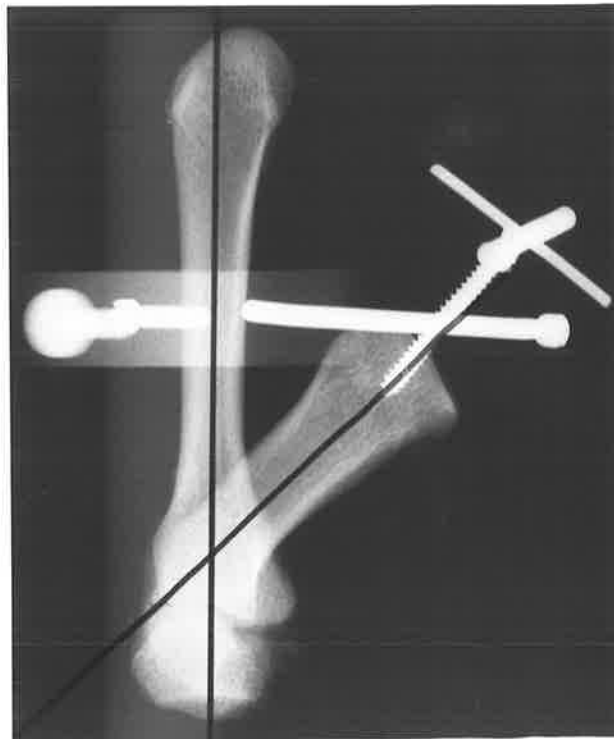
Radiographic measurement of opposition.
